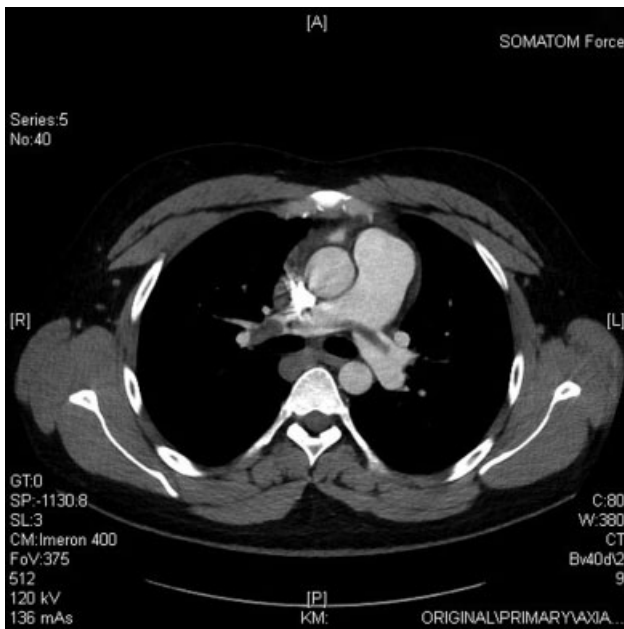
Computed tomography angiography of the chest: central and bilateral pulmonary emboli before heparin/alteplase therapy.
